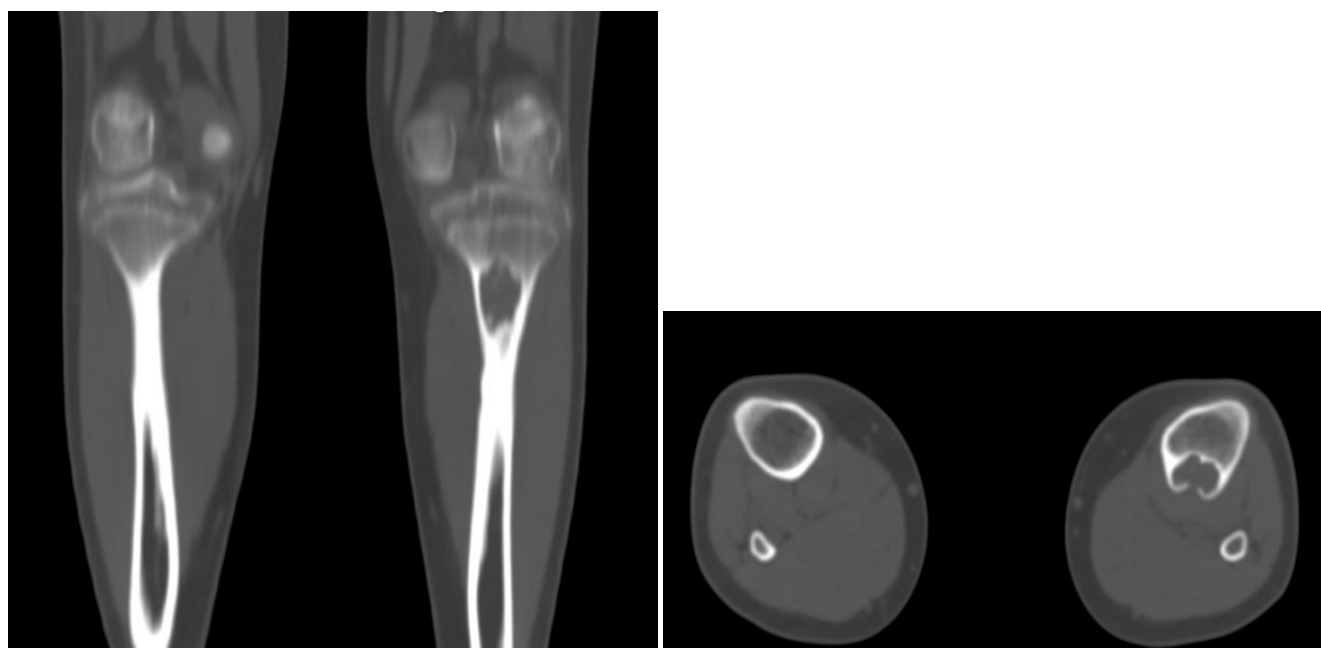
Computed tomography imaging of the 11-year-old boy with residual anaplastic ependymoma. Coronal and axial computed tomography demonstrated eccentric lesion with central radiolucency and cortical defect in the left proximal tibia.
